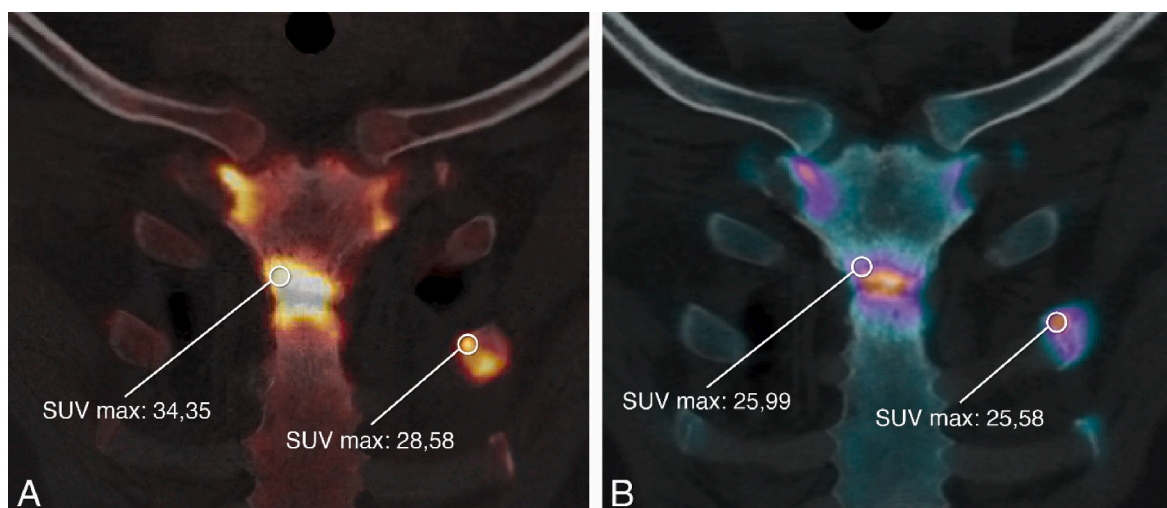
Two different coronal CT view [18F]NaF-PET/CT-scans of the same patient with adult CNO, performed 6 months apart. A: sclerosis, hyperostosis and erosive changes at the level of the joint between the manubrium and corpus of the sternum, with increased uptake of [18F]NaF at this level, in the manubrium sterni, at the level of the first sternocostal joints bilaterally, and at the 3rd costochondral junction on the left. B: after treatment, radiological features remain stable, although there is an evident decrease in the activity of the disease, as also shown by the decreased SUV max values.
